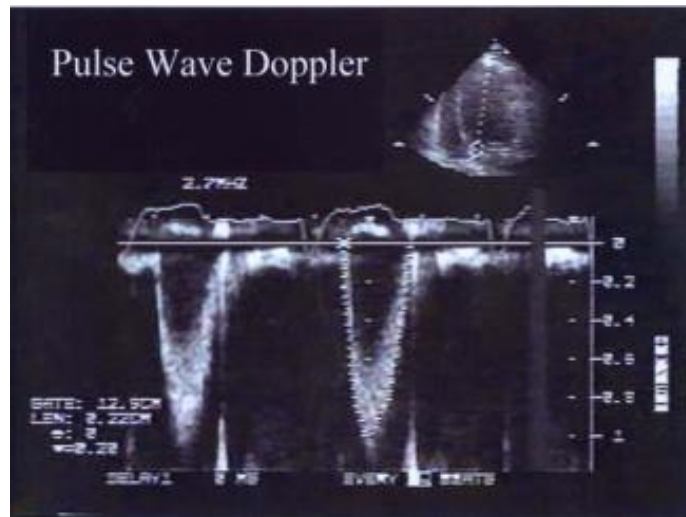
PW Doppler recording of left ventricular outflow track velocity obtained from apical window. Because flow is away from transducer, velocities are displayed below baseline. Notice narrow spectral pattern during flow acceleration and deceleration and wider dispersion seen during mid-systole. Degree of dispersion indicates range of blood flow velocities detected within sample volume.
